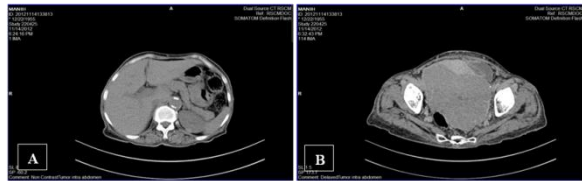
Abdominopelvic CT scan examination revealed an inhomogeneous mass in pelvic cavity (A) and normal liver (B).
